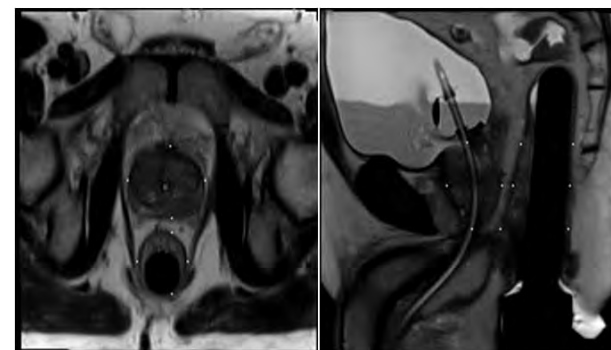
Axial and sagittal MRI slice showing Points of Interest (white dots)
